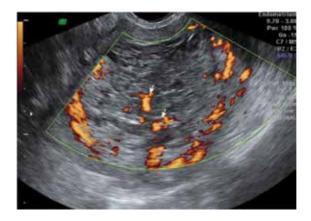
Ultrasound image in gray and color Doppler scale showing a case of choriocarcinoma with invasion of the myometrium and beyond.
